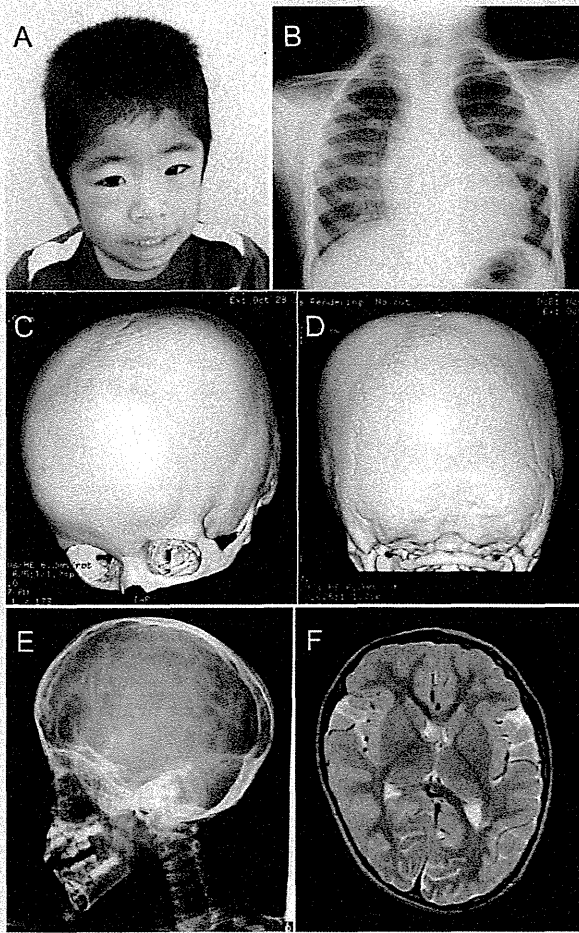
Photograph of patient 1 at 2^{1/2} years of age. A: “Coarse” facial appearance including long face, full cheeks, thick eyebrows, puffy eyelids, epicanthus folds, depressed nasal bridge with anteverted nostrils, long philtrum, and large mouth with thick vermillion to the lips. B: Chest radiograph showing cardiomegaly [CTR 0.65]. C,D: Skull 3D-CT showing synostosis of bilateral coronal sutures and anterior aspect of the sagittal suture. E: Skull radiograph showing impression of cerebral gyri. F: Brain MRI showing scalloping of the calvarial inner table and normal brain structures.
